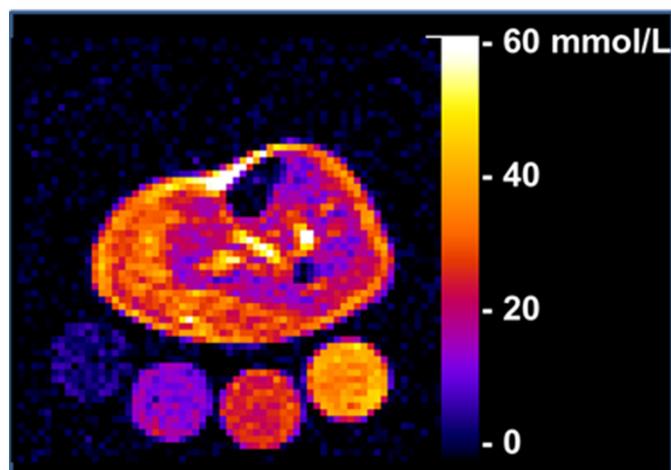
²³Na magnetic resonance imaging (²³Na-MRI) of lower leg showing magnitude of sodium signal intensity. Tubes with solutions containing 10, 20, 30, and 40 mmol/l of NaCl are arranged below the extremity (left to right), thereby allowing us to calibrate tissue sodium.
